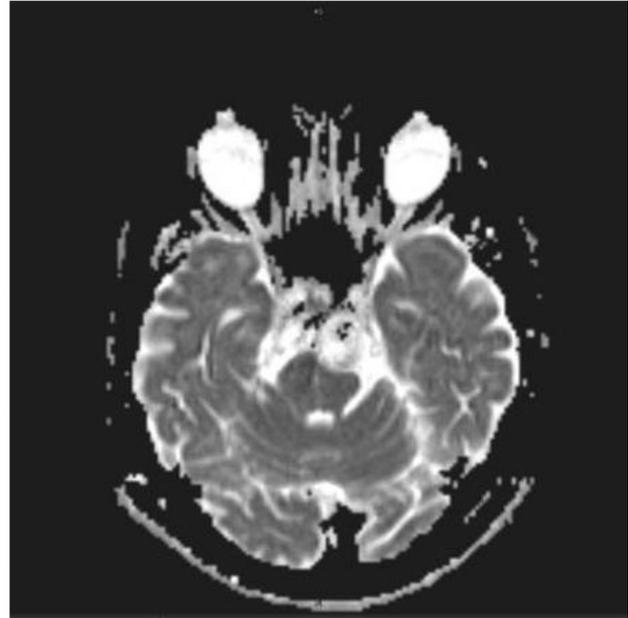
T2 axial tirm dark fluid-cranial MRI.
